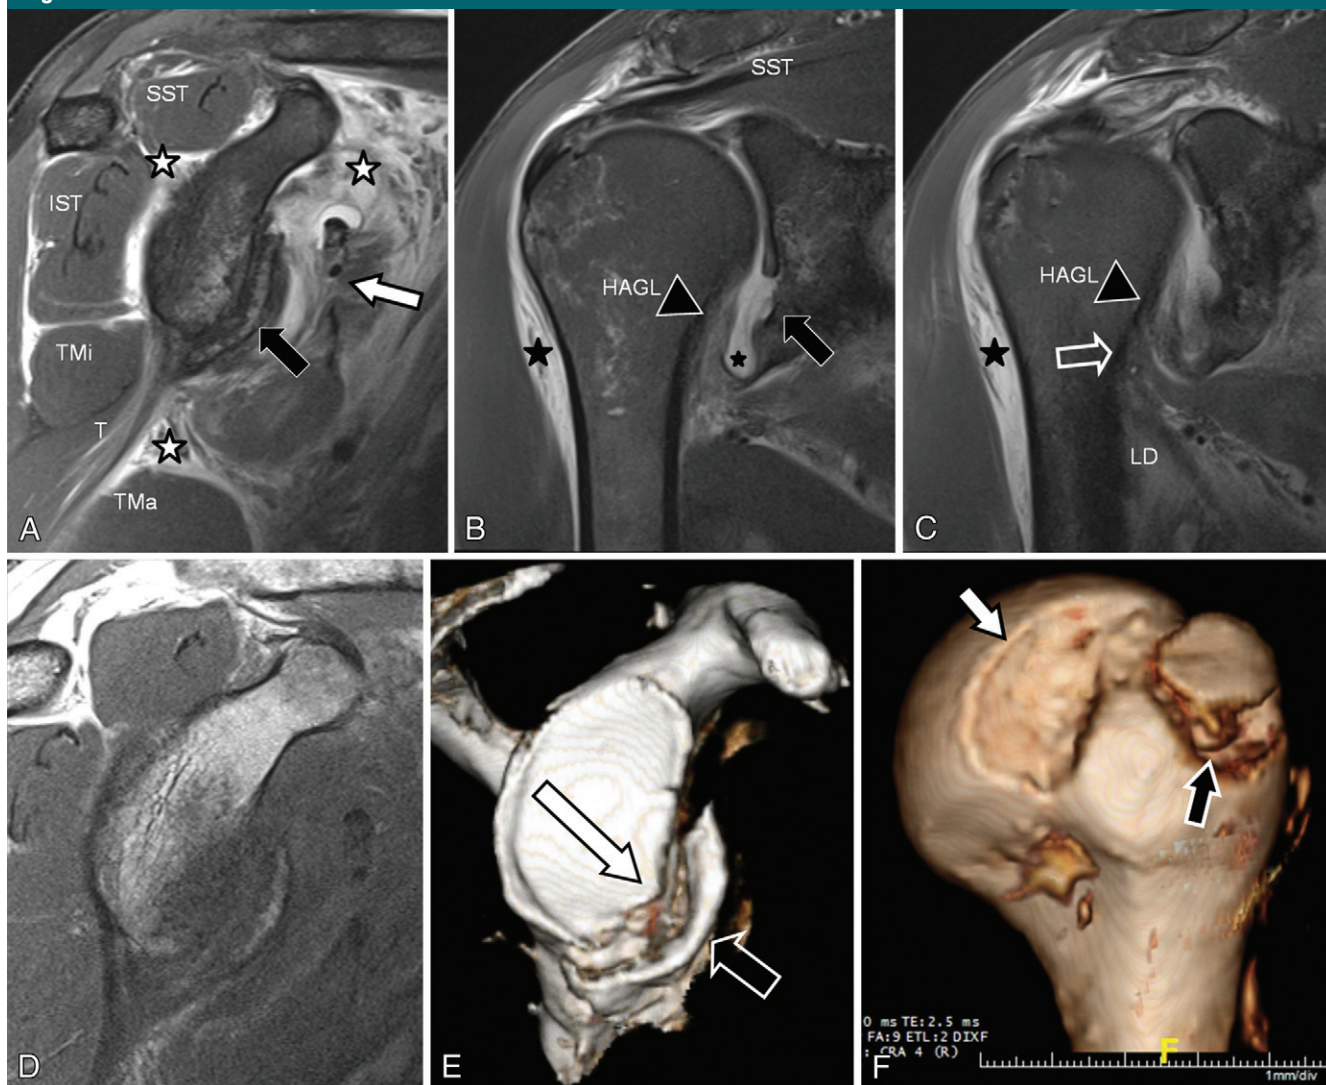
MR images of acute recurrent anterior shoulder dislocation with Bankart fracture in a 64-year-old man. *A*, Sagittal and, *B*, *C*, coronal fat-suppressed T2-weighted images demonstrate extensive periarticular posttraumatic swelling (☆) with high-grade partial thickness tears of the subscapularis myotendinous junction (white arrow) and humeral muscular insertion (open arrow) as well as strains of the supraspinatus (*SST*), infraspinatus (*IST*), teres minor (*Tmi*), latissimus dorsi (*LD*), triceps (*T*), and teres major (*Tma*) muscles. Glenohumeral and subacromial subdeltoid effusions (★), as well as humeral avulsion of the inferior glenohumeral ligament (HAGL ▲) and a detached and mildly displaced Bankart fracture (black arrow). *D*, Sagittal T1-weighted image demonstrates a displaced Bankart fracture fragment. The defect in the anteroinferior glenoid rim is somewhat ill defined. *E*, Three-dimensional MR reconstruction demonstrates the amount of glenoid bone loss, glenoid fracture margin (white arrow), and adjacent fracture fragment (open arrow) to a better extent than the conventional MR images. *F*, Three-dimensional MR reconstruction of the humeral head demonstrates a mildly displaced avulsion fracture of the greater tuberosity at the insertion of the supraspinatus tendon (black arrow), as well as an impacted Hill-Sachs lesion (white arrow).
